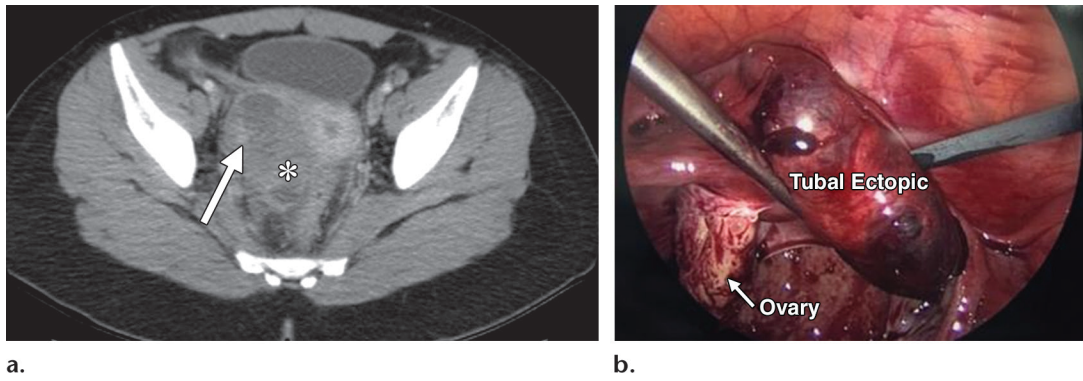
Ectopic pregnancy in a 19-year-old woman with right lower quadrant pain. (a) Axial contrast-enhanced CT image shows a complex right adnexal mass (arrow), with anterior displacement of the broad ligament and surrounding lateral pelvic fat stranding (*). US disclosed a tubal ectopic pregnancy. (b) Intraoperative photograph shows a right tubal ectopic pregnancy.
